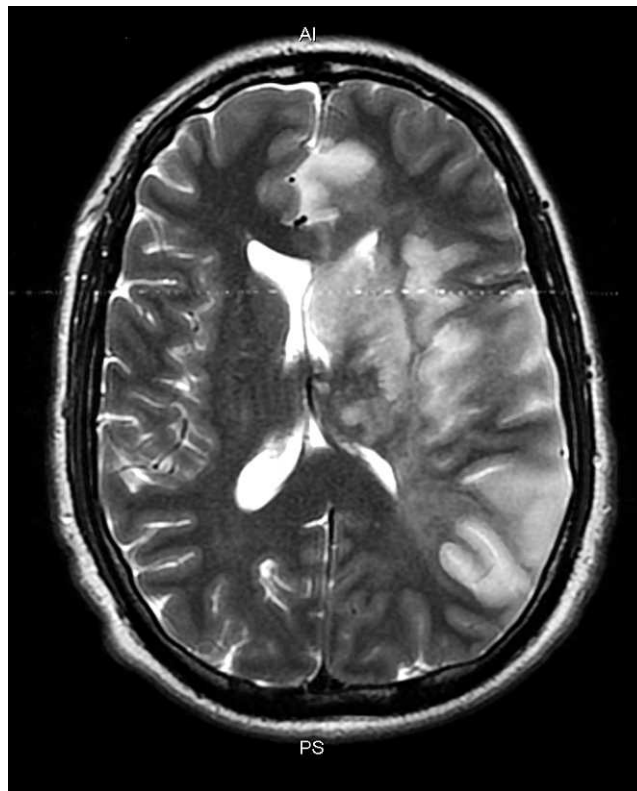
Magnetic resonance imaging fluid-attenuated inversion recovery showing a large area of restricted diffusion involving the left middle carotid artery and left anterior cerebral artery distributions, compatible with infarction. AI, anterior; PS, posterior.
